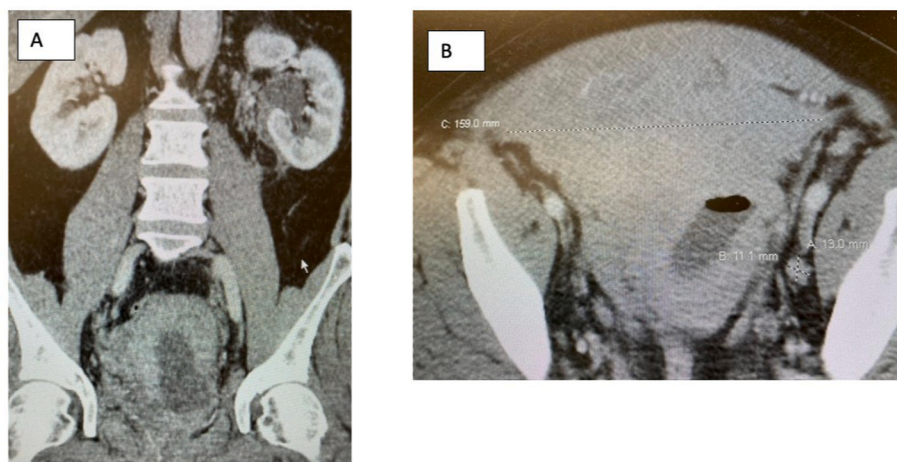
CT Scan of Bladder Mass
